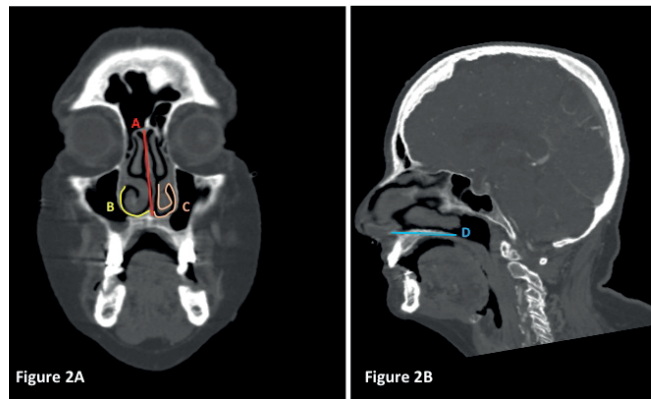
Measurements performed in the radiological study. A: in the midline of the sagittal plane. A: Coronal view of a CT scan. Line A: Anterior height of the septum. Line B: Anterior length of the SNFIM flap. Line C: Anterior length of the ENFIM flap. B: Sagittal view of a CT scan in the middle line. Line D: Sagittal length of the SFIM and ENFIM flaps.
